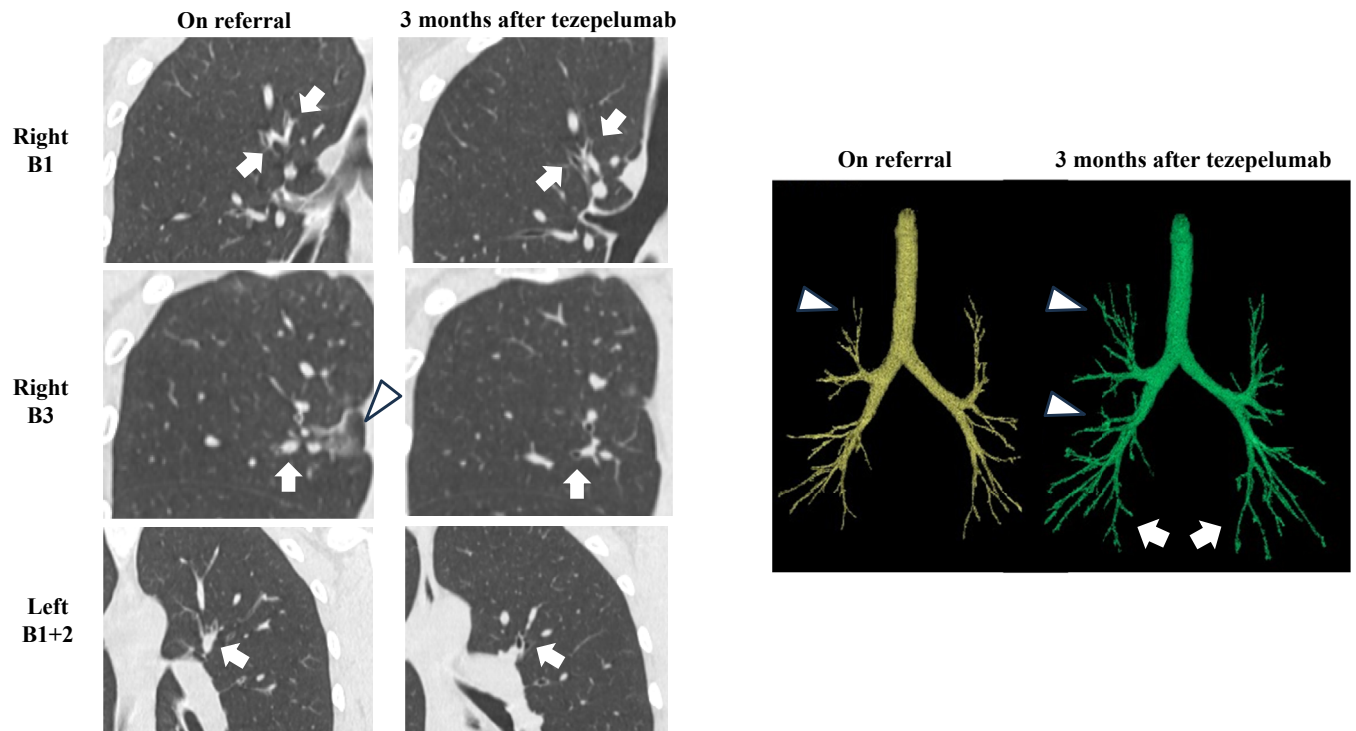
Chest CT images on referral and 3 months after tezepelumab treatment. Arrows indicate mucus plugs, and the arrowhead indicates areas of infiltration. Three-dimensional bronchial tree visualizations on referral and 3 months after tezepelumab treatment are also shown. The arrowhead indicates a bronchial tree defect, and arrows further indicate dilatation of the peripheral bronchial trees.
